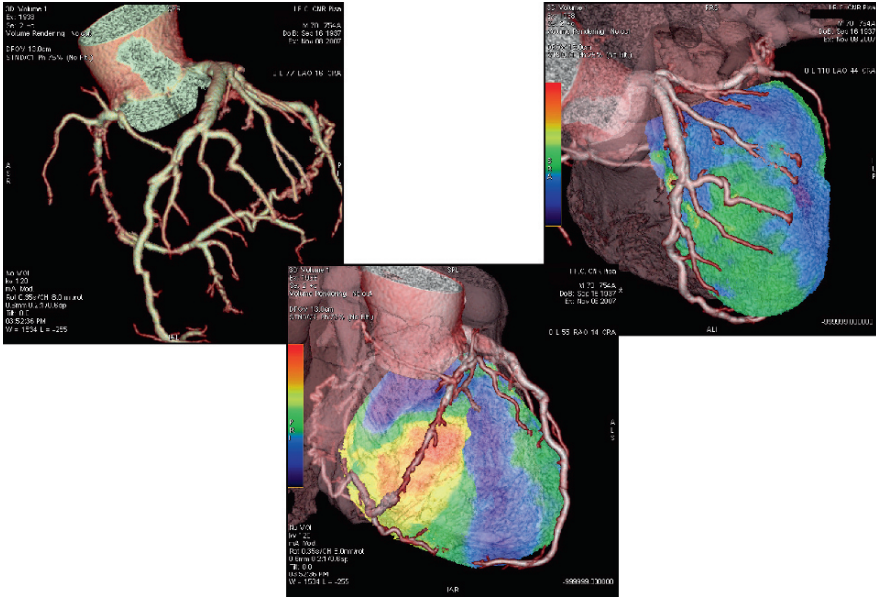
An example of hybrid PET–CT imaging, with simultaneous representation of coronary anatomy (*left*) and perfusion (*right and middle panels*). (Courtesy of Dr. Danilo Neglia, Head of Cardiac PET Lab, Institute of Clinical Physiology, Pisa, Italy)
